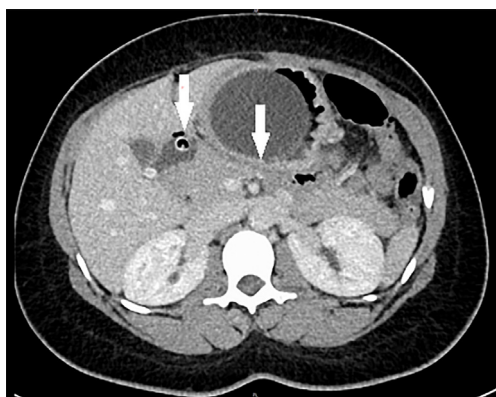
Computed tomography of the sagittal plane. The arrows refer to the dislodged filling catheter in the duodenum and the slightly compressed corpus of the pancreas by the balloon.
